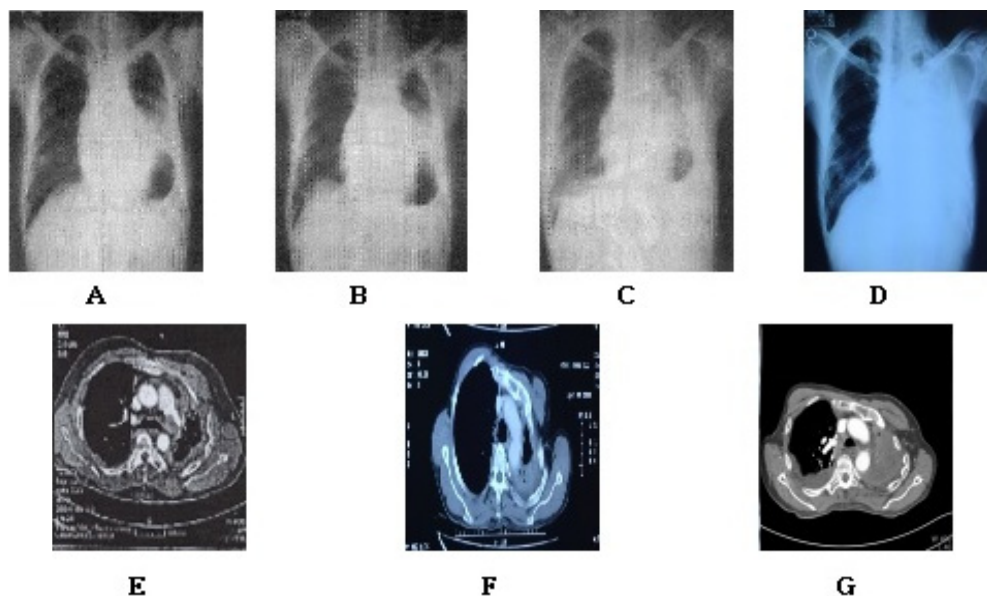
The change of chest x-ray and chest CT in case 1.
